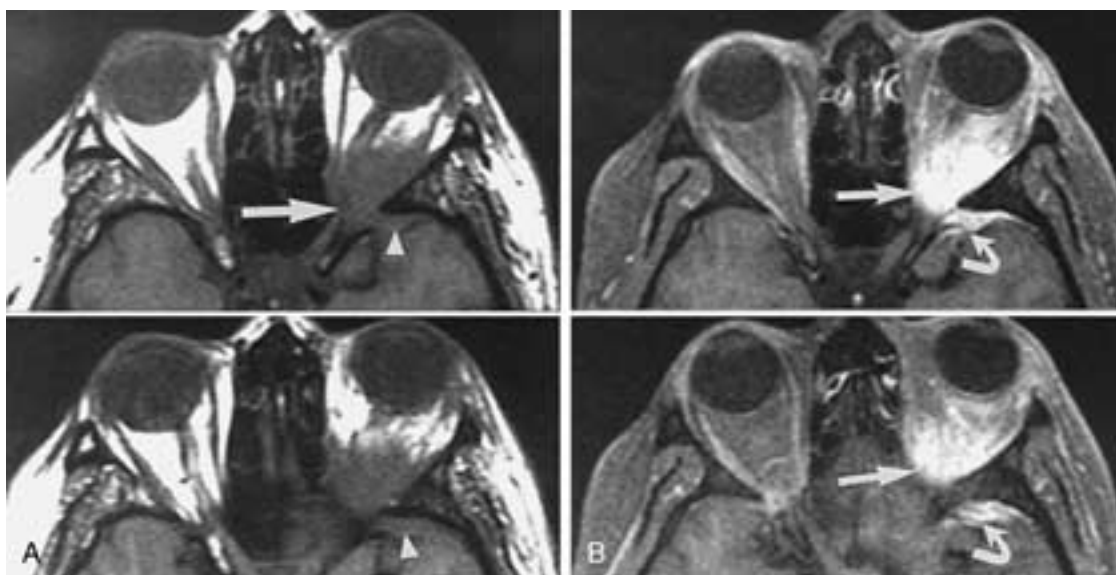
Orbital sarcoidosis presenting as superior orbital fissure syndrome. A, Unenhanced axial T1-weighted (400/25, TR/TE) MR images. Note the infiltrative process involving the orbital apex on the left side (*large arrow*). Note extension through the superior orbital fissure into the left temporal epidural space (*arrowheads*). B, Enhanced axial fat-suppressed, T1-weighted MR images show marked enhancement of this sarcoid granulomatous infiltration (*straight arrows*). Note the abnormal enhancement in the left temporal fossa (*curved arrows*). (From Mafee MF et al. Sarcoidosis of the eye, orbit, and central nervous system. Role of MRI. Radiol Clin North Am 1999;37:73–87.)
